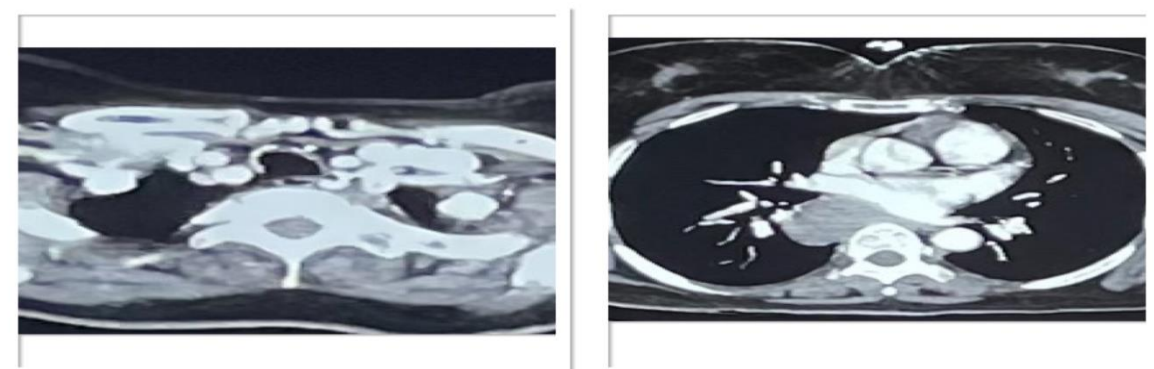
Contrast-enhanced computed tomography (CECT) of the chest showing calcified nodular lesions along the anterior wall of the trachea (arrows). A foregut duplication cyst is also seen in the subcarinal region extending into the middle and posterior mediastinum.
